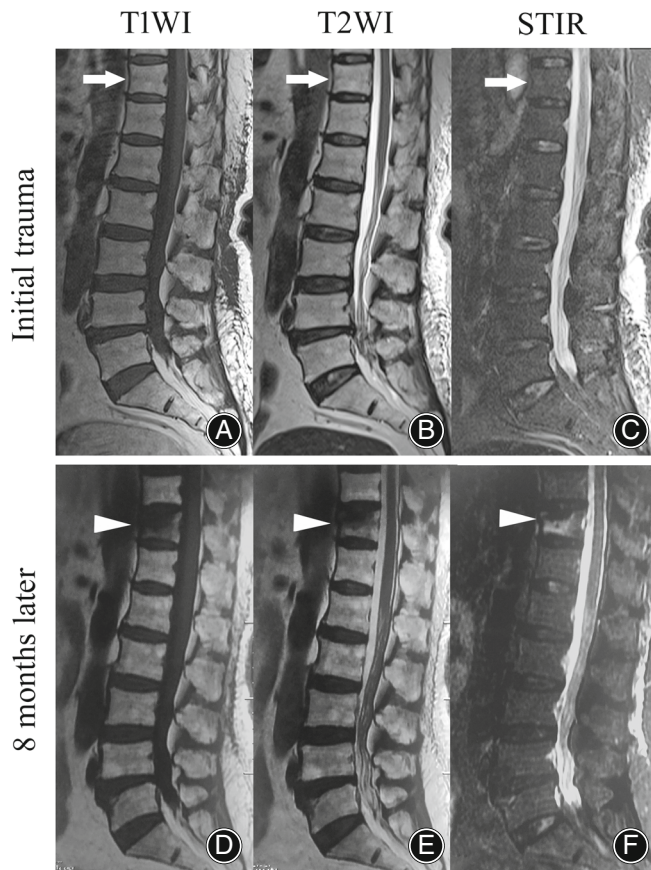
Lumbar MRI on sagittal planes taken immediately after the trauma and 8 months later. The integrity and connectivity of the vertebra following the initial trauma are not interrupted, and the marrow signal is even. (A–C, arrows) After asymptomatic 8 months, the pain is onset again, all MRI sequences show the wedge-shaped changes of T11 vertebra, and the abnormally confined hypointensity area underneath the upper endplate (D–F, arrowheads), indicating the formation of IVC. T1WI T1-weighted image, T2WI T2-weighted image, STIR short-tau inversion recovery
